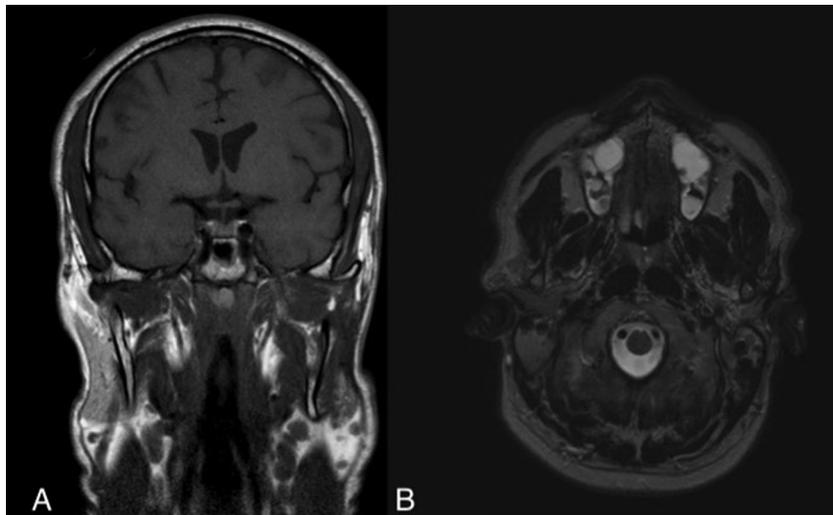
Post-operative MRI scans: showing complete excision of intramuscular lipoma in coronal (6-A) and axial (6-B) scans with no evidence of recurrence 1 year post-operatively.
